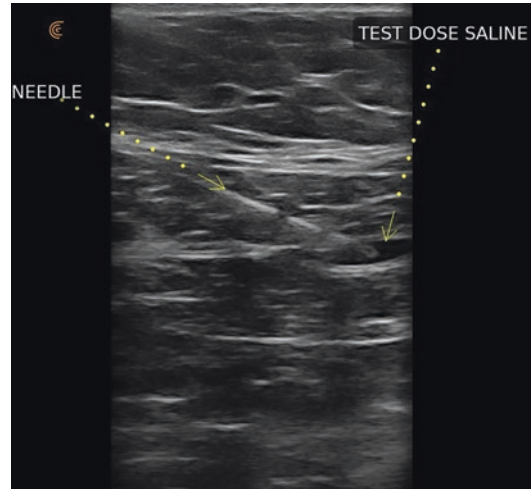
Grayscale ultrasound image of chest wall showing Sonoblock® needle in the space between pectoralis major and minor muscles. A test dose of saline is injected producing an anechoic space between the muscles
